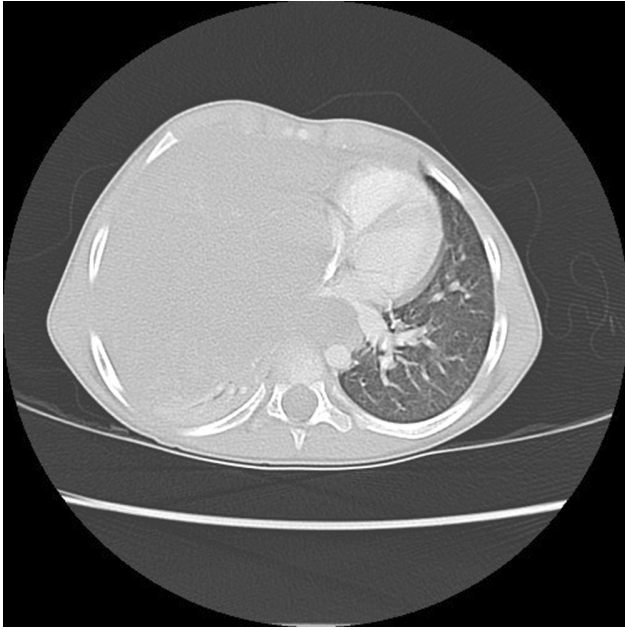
Initial Computed Tomography Scan Showing Extension of the Pulmonary Mass to the Anterior, Middle, and Posterior Mediastinum
